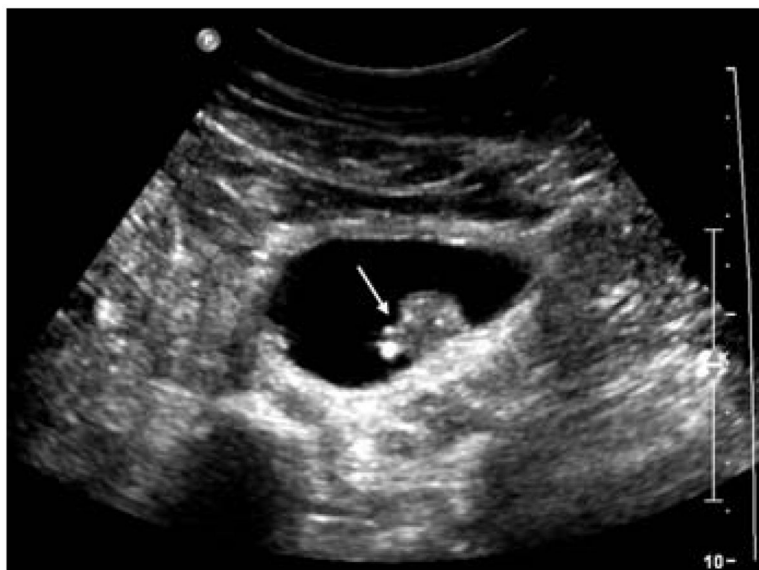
Sagittal ultrasonography image of the urinary bladder, demonstrating a lobulated mucosal mass with calcifications (*arrow*), representing transitional cell carcinoma of the bladder.
